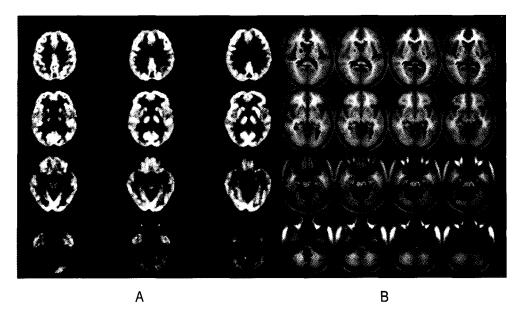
Fifty-three years old female with multiple system atrophy (cerebellar type). Axial image of F-18 FDG PET and SPM results comparing with age matched normal controls show significant hypometabolism of pons, cerebellum, medulla and putamens.
